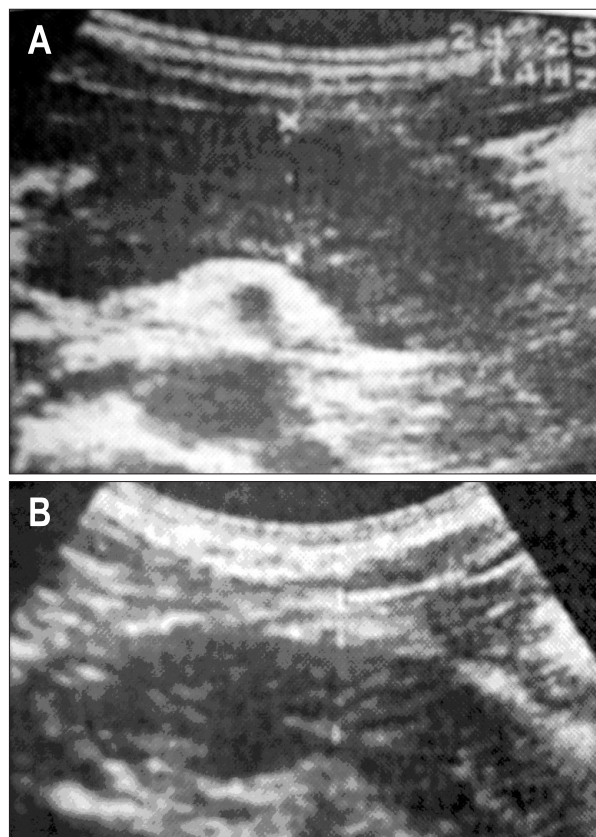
(A) Sonographic picture of enlarged sausage-like pancreas prior to steroid treatment and (B) normalization of this finding after 6 months of steroid treatment.
